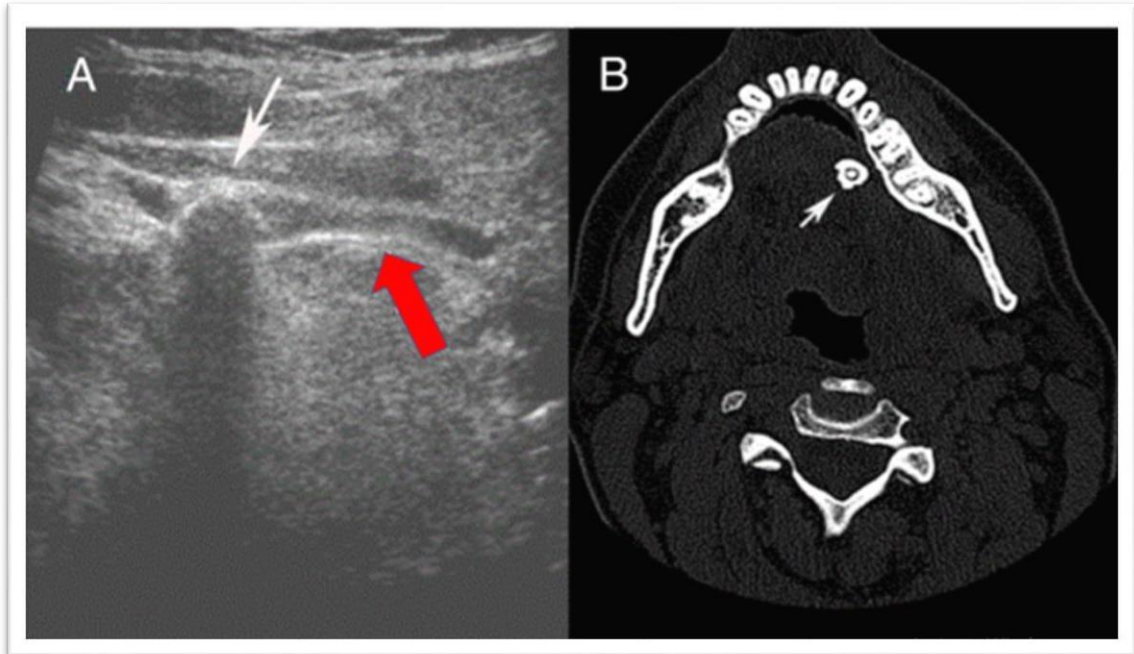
A) US of neck showing a stone in the left submandibular gland (white arrow) about 1 cm and the dilatation of the duct (red arrow). B) Neck axial view of the CT scan showing the stone in the left submandibular gland measuring 1 cm (white arrow). Adapted from: El-Rasheedy et al. (97)
